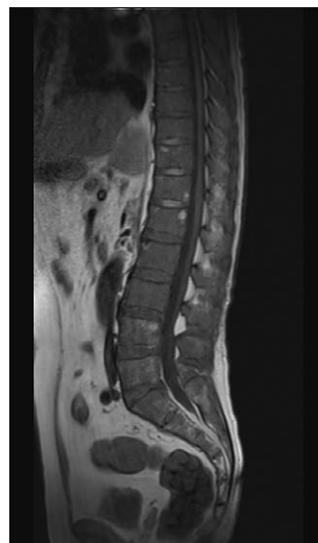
T1-weighted magnetic resonance imaging shows diffuse low signal intensity throughout the vertebral spine.
